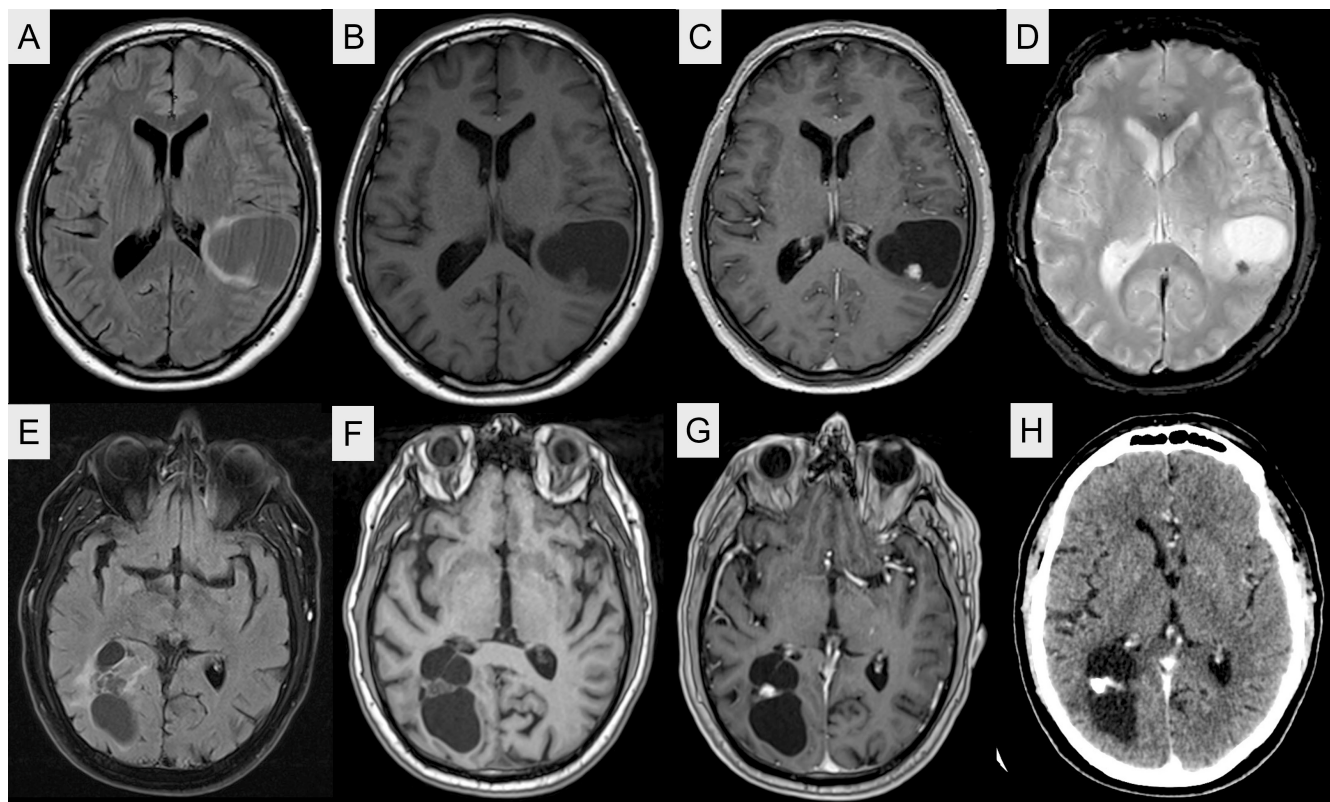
Axial brain MRI and CT images of two representative cases. (A–D) Right fronto-parietal lesion showing a large cystic component with a mural nodule on FLAIR (A) and T1-weighted (B) images, thin peripheral and nodular enhancement after gadolinium administration on post-contrast T1-weighted imaging (C), and a marked susceptibility effect from haemorrhagic foci on susceptibility-weighted imaging (D). (E–H) Right occipital lesion with a similar cystic cavity and an eccentric mural nodule on FLAIR and T1-weighted images (E, F), demonstrating nodular enhancement on post-contrast T1-weighted imaging (G); CT scan (H) showing hyperdensities associated with microcalcification.
